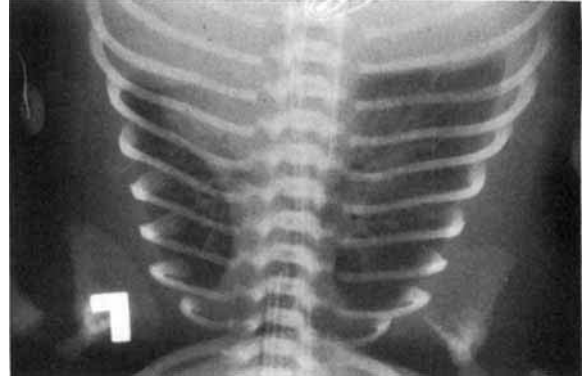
Chest radiograph. Note elevation of left hemidiaphragm, consistent with documented eventration. Bilateral effusions are present, with only the right clearly visible here.
